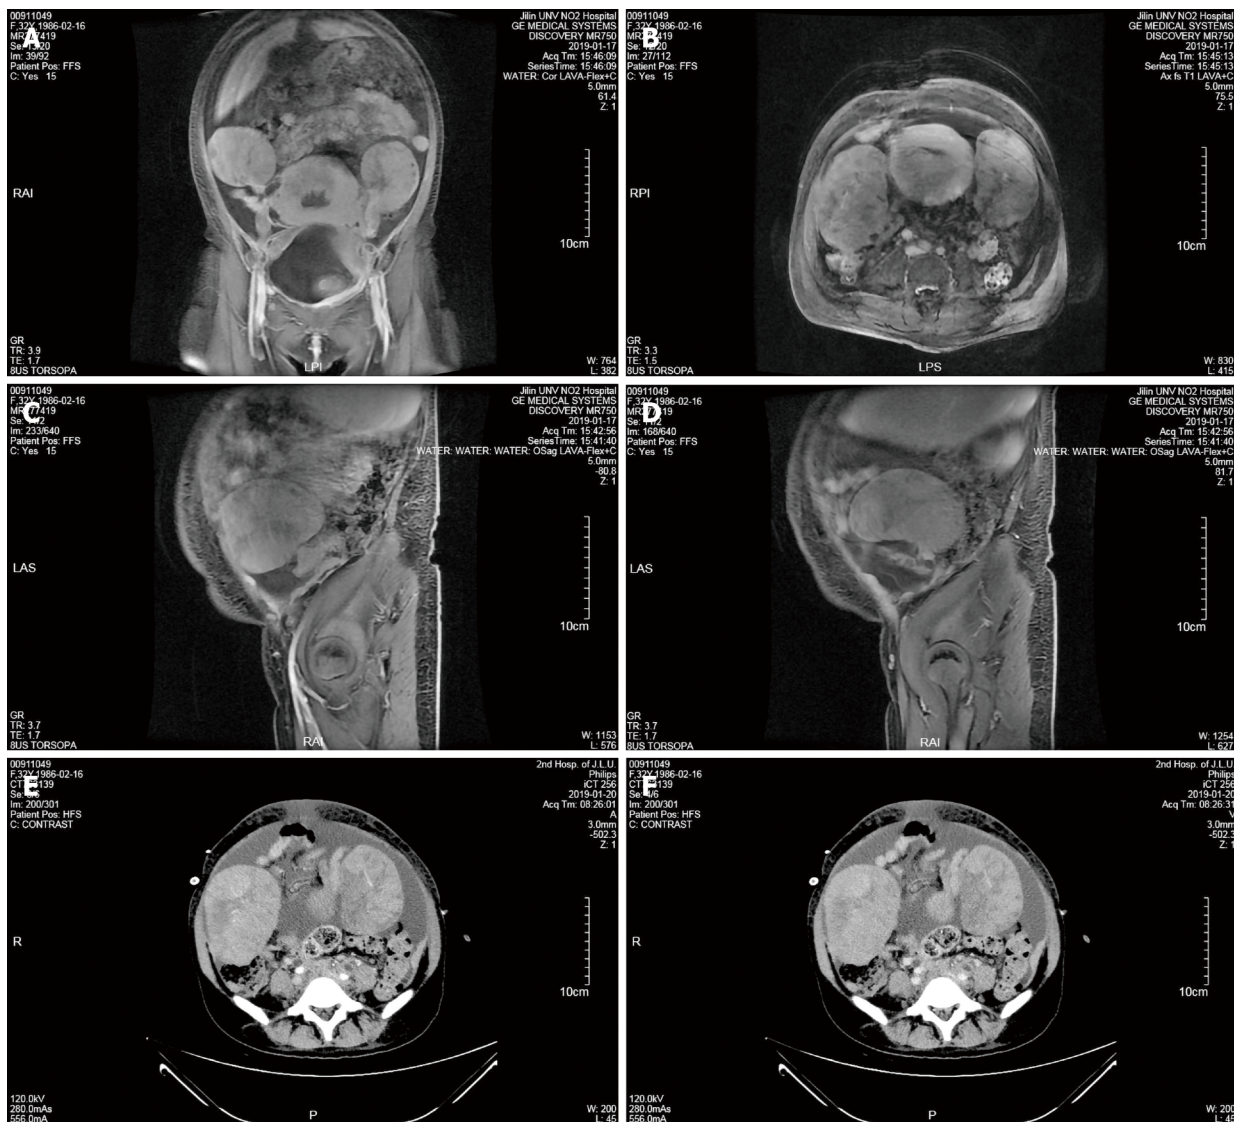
Magnetic resonance imaging and computed tomography imaging. A and B: Coronal (A) and axial (B) images showed bilateral adnexal malignant tumors; C and D: Sagittal images showed masses in the left (C) and right (D) adnexal area; E and F: Computed tomography images of the arterial phase (E) and venous phase (F) showed bilateral adnexal malignant tumors.
